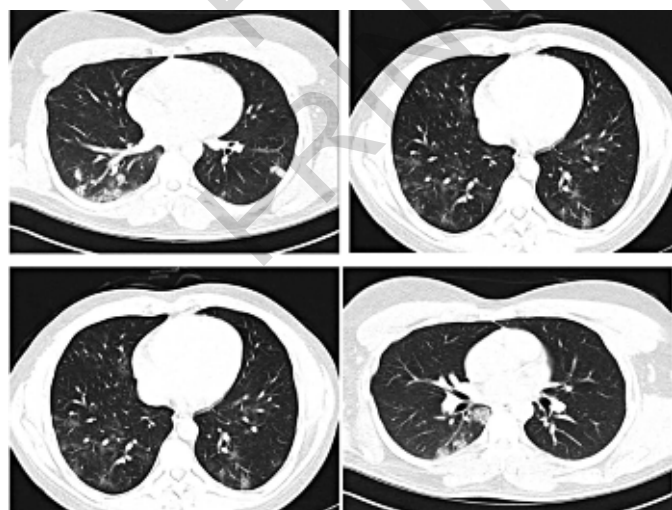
Abnormal CT findings.
